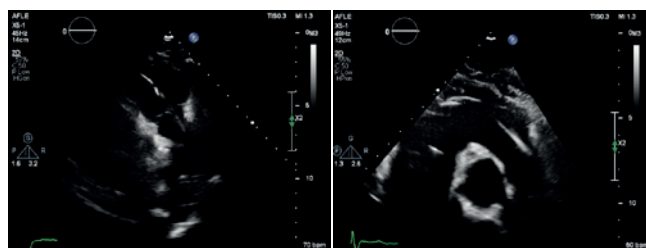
The left image shows the right ventricular outflow view on 2D echocardiography showing the MPA and pulmonic valve. An echogenic structure can be seen passing through the pulmonic valve between the leaflets which resembles a pacing lead. The right image shows the parasternal short axis view at the aortic level on 2D echocardiography with reduced depth to visualise the RVOT. An echogenic structure which resembles a pacing lead can be seen passing through the tricuspid valve and curving through the RVOT and into the MPA.
